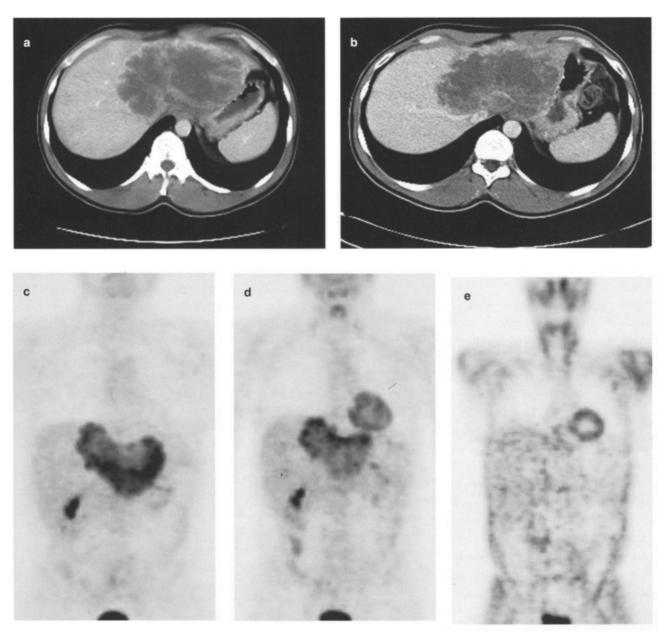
1. Response to therapy assessed with FDG-PET following two therapy doses with SIR-Spheres in a patient with liver metastasis from a primary of unknown origin.
